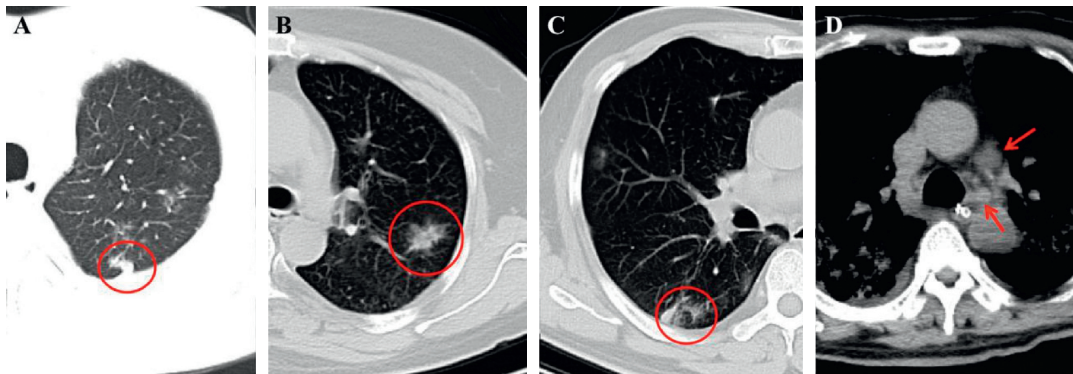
(a) A 46-year-old male COVID-19 patient with fever. CT scan demonstrates a subpleural nodule in the left upper lobe (red circle). (b) A 50-year-old female COVID-19-confirmed patient with dry cough for 4 days. The nontypical halo sign can be seen in the left upper lobe (red circle). (c) The same patient in (a) and the CT displays a nontypical reversed halo sign in the right lower lobe (red circle) in the follow-up CT image. (d) A 60-year-old male COVID-19 patient with initial symptoms of dry cough and fever for 3 days. CT scan shows the enlarged lymph nodes in the mediastinum (red arrows), and this patient is diagnosed coinfection with other bacteria.
